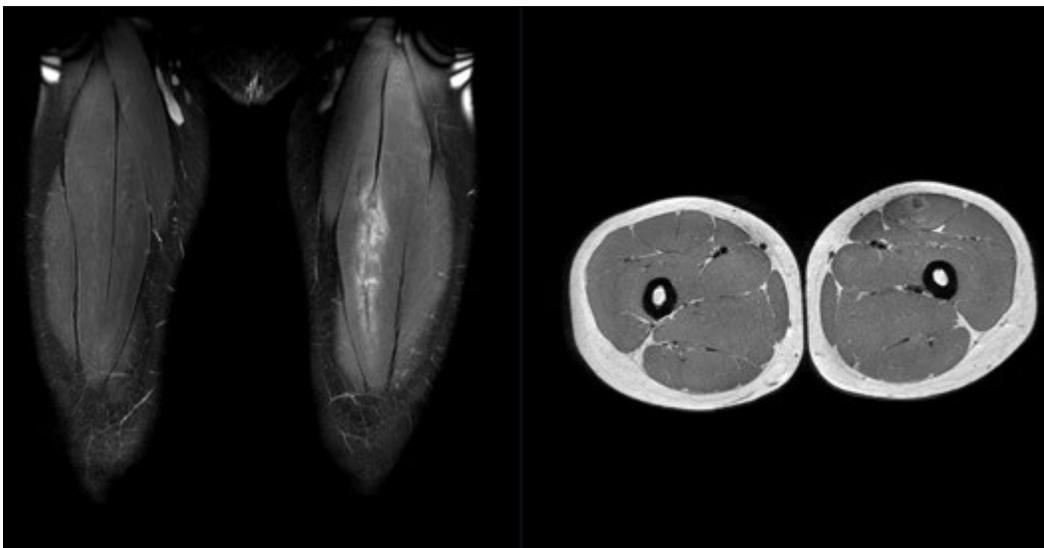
Coronal and axial MRI demonstrating intramuscular tendon injury of the indirect head of the rectus femoris (indirect head) on the left side.
